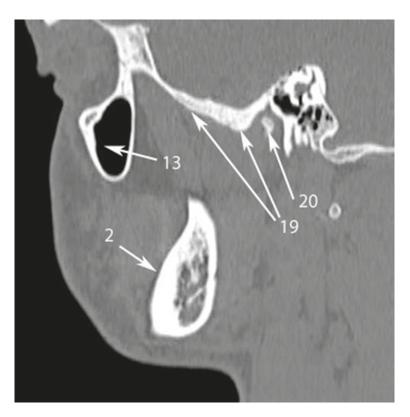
Sagittal CT scan at the level of angle of the madible. *Numbers* with *arrows* denote the following anatomical structures: 2 – mandible; 13 – maxillary sinus; 19 – greater wing of the sphenoid bone; 20 – mandibular condyle.
